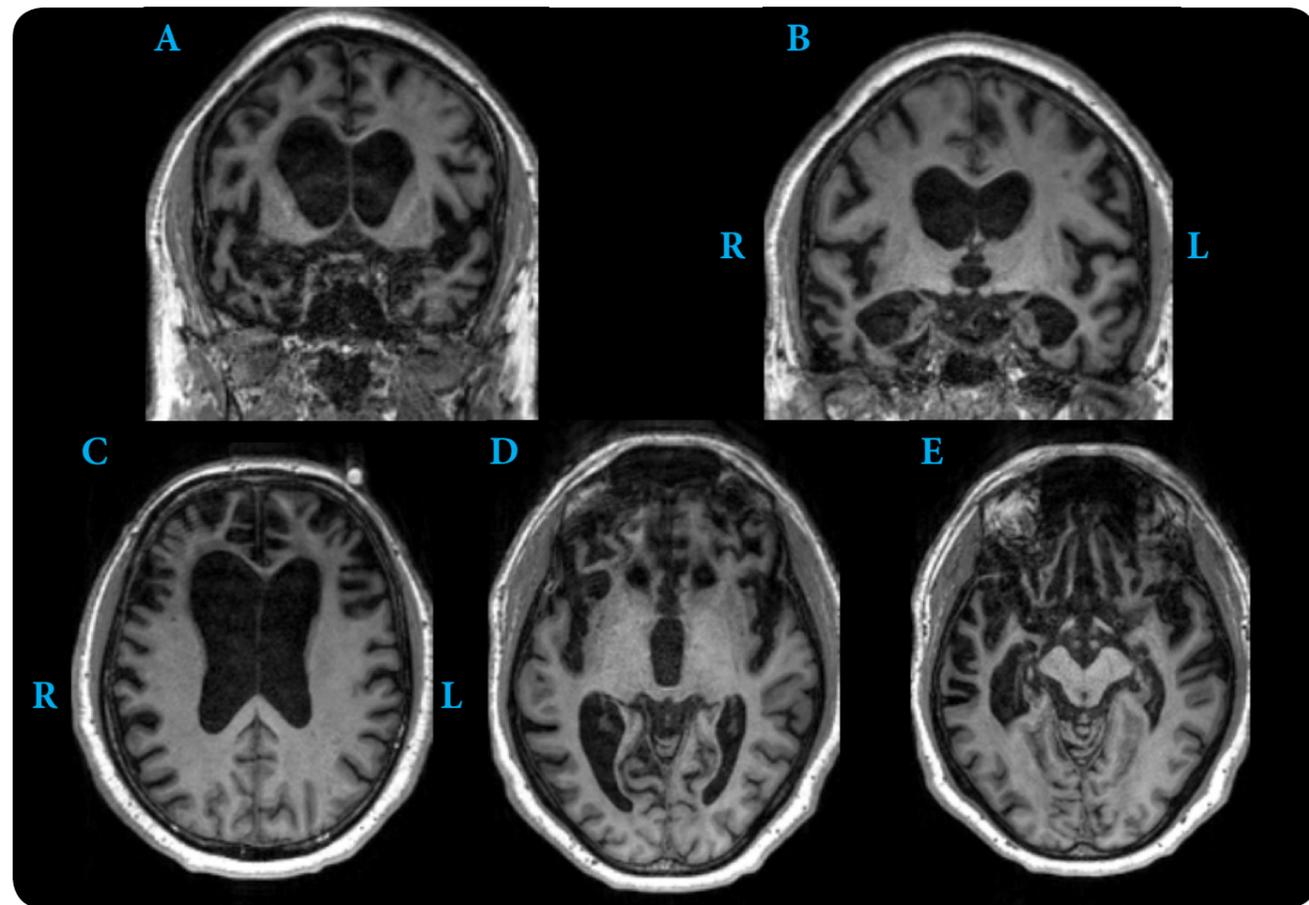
Case 2 brain MRI of Mrs. Y showing atrophy in the coronal plane (A, B) and axial plane (C, D, E.)
